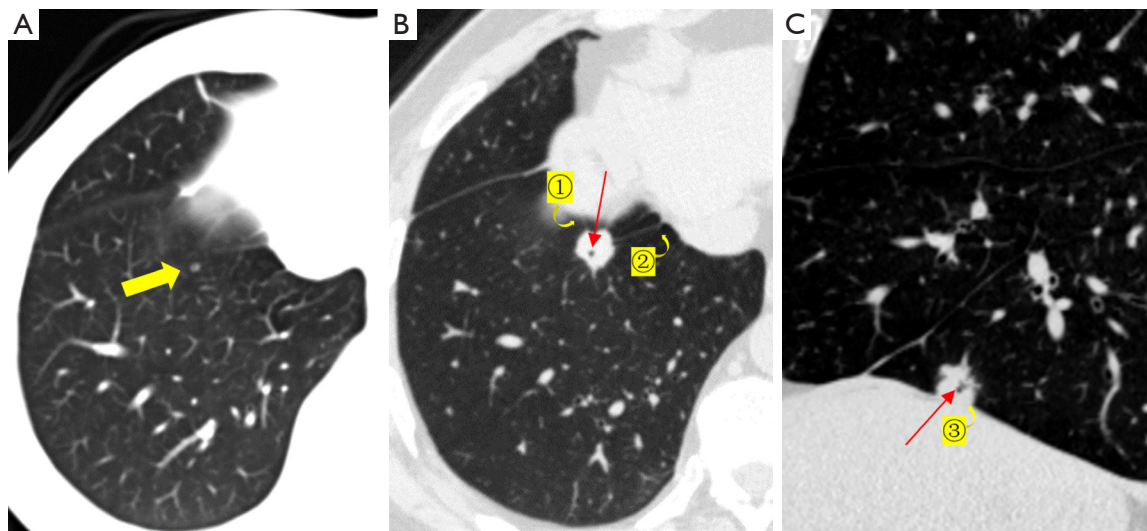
Primary peripheral invasive lung adenocarcinoma. M, 59 y/o, 5 years after rectal cancer surgery. (A) The first CT scan showed a 4-mm-diameter mGGN (as indicated by the yellow arrow) in the anterior basal segment of the right inferior lobe with clear borders; CT value: -567.9 ± 160.2 HU; CTR >0.5 ; no malignant signs. (B,C) On the follow-up examination after 1418 days, the mGGN transformed into a SPN with clear borders, a 20-mm-diameter, and a CT value of -14.2 ± 106.3 HU, with a significant increase in the nodule volume (VDT: 309 days), lobulation, spiculation, the pleural indentation sign (① c-type + ② b-type + ③ a-type, as indicated by the curved arrows), and air bronchus sign (type III, coexistence of stenosis and dilatation, as indicated by the red arrows). M, male; y/o, years old; CT, computed tomography; HU, Hounsfield unit; mGGN, mixed ground-glass nodule; CTR, consolidation tumor ratio; SPN, solitary pulmonary nodule; VDT, volume doubling time.
